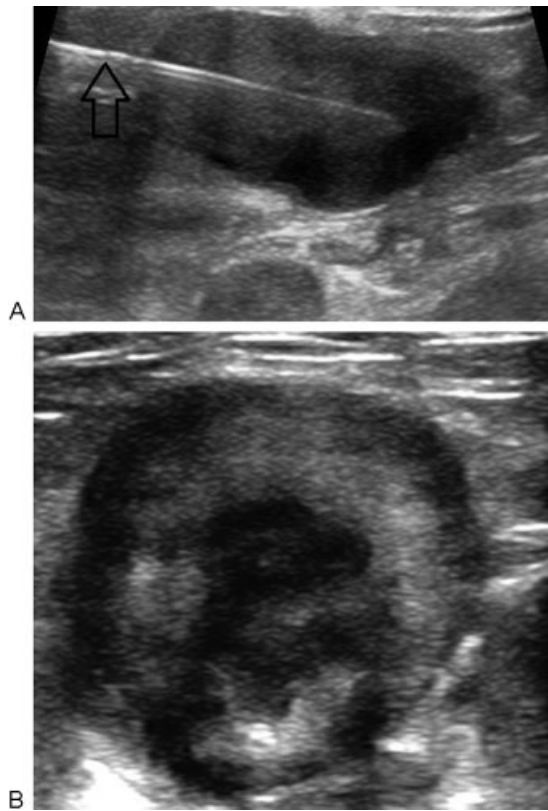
Painful quadriceps desmoid tumor limiting function. (A) A Whitaker needle (arrow) was placed into the tumor for slow intralesional injection of 2 mL of 50% acetic acid. Real-time ultrasound was used to observe for peritumoral extravasation. (B) Two-month follow-up ultrasound demonstrating hollowed hypochoic central necrosis. The patient's pain reduced from 9/10 to 3/10.
